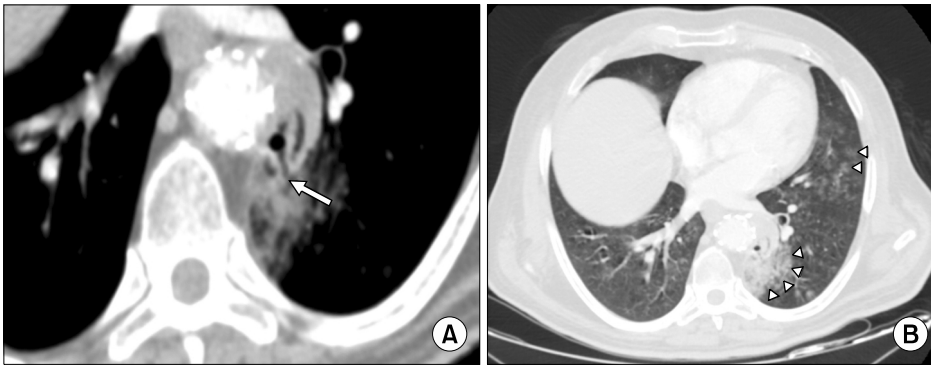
Minimum intensity projection reformation (A) shows the presence of a significant proportion of air in the aneurysmal sac with a linear air image with an interruption of the aortic wall (arrow); (B) an axial contrast-enhanced multidetector computed tomography scan showing reduction of atelectasis and an increase in ground-glass opacities (arrowheads) in the absence of endoleaks.
